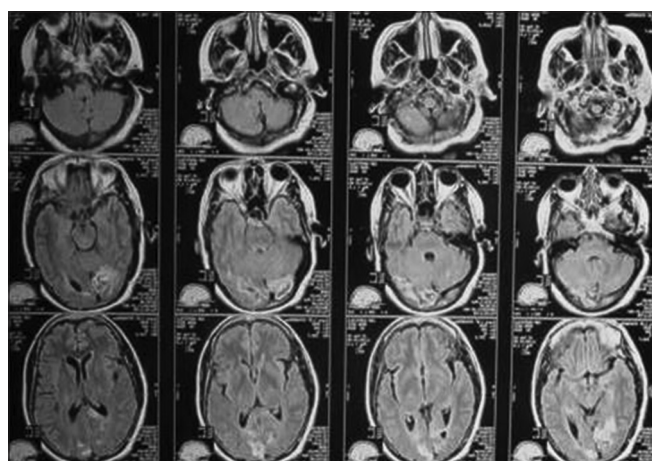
Showing magnetic resonance imaging of the brain showing significant resolution of lesions at 2 months postoperative
